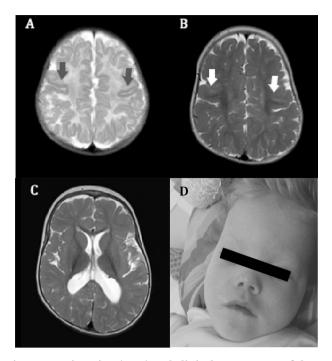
MR imaging (A–C) and clinical appearance of the index patient (D). A. T2-image at 7 weeks showing polymicrogyria of the central regions (arrows). B. Follow up T2 image at 19 months reveals a progression at the same area to mild pachygyria (arrows). C. For 19 months hyperintensity within the white matter related to the delayed myelination. D. Facial stigmatas at the age of 20 months showing the high forehead, hypertelorism, and epicanthus. Also notable, hypotonia of the facial musculature. (Photo published with parents' consent).
